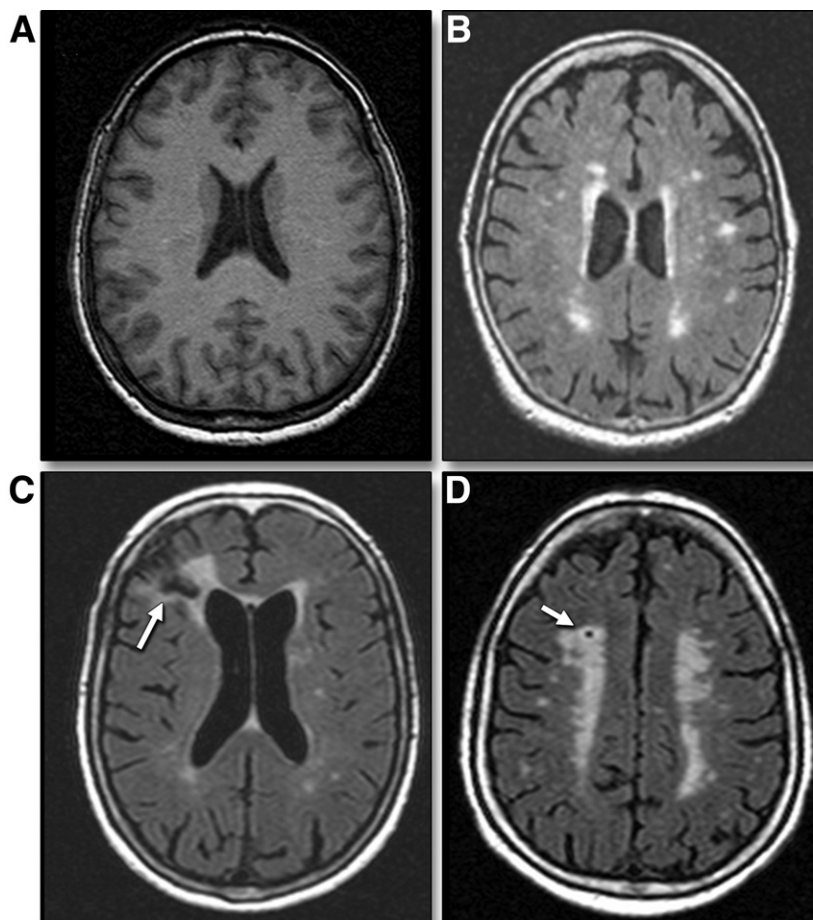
Subclinical Brain Lesions by MRI
